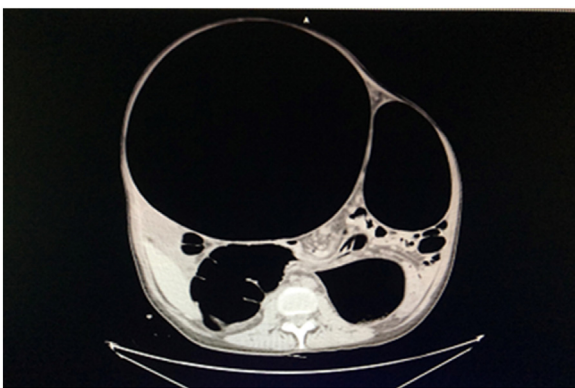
Suspicious megacolon in CT-scan.
